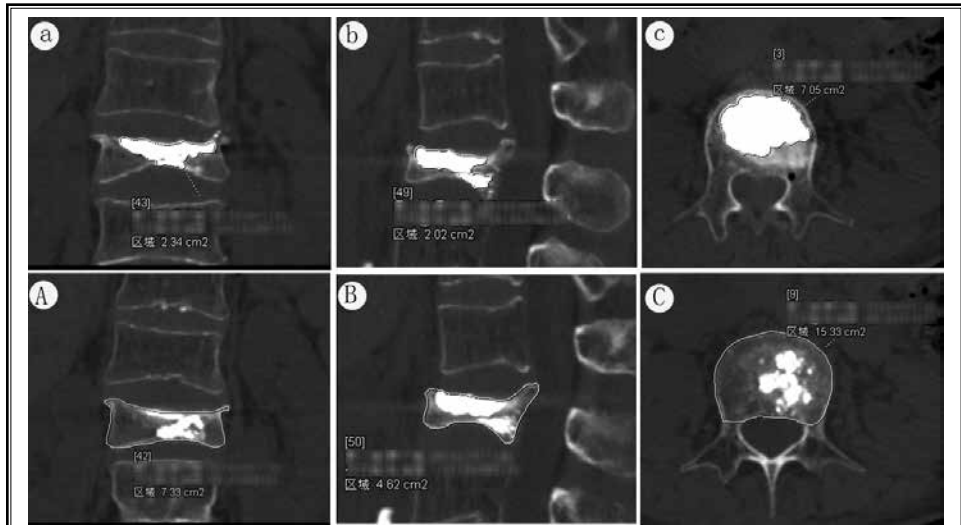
Measurement of bone cement dispersion on 3D CT scans. We measured the largest area of bone cement (a, b, c) and the largest area of vertebral body (A, B, C) in the axial, coronal, and sagittal planes, respectively. The bone cement dispersion was equal to the sum of the largest area of bone cement in the axial, coronal, and sagittal planes divided by the sum of the largest area of the vertebral body in the axial, coronal, and sagittal planes. 3D, 3-dimensional; CT, computed tomography.
